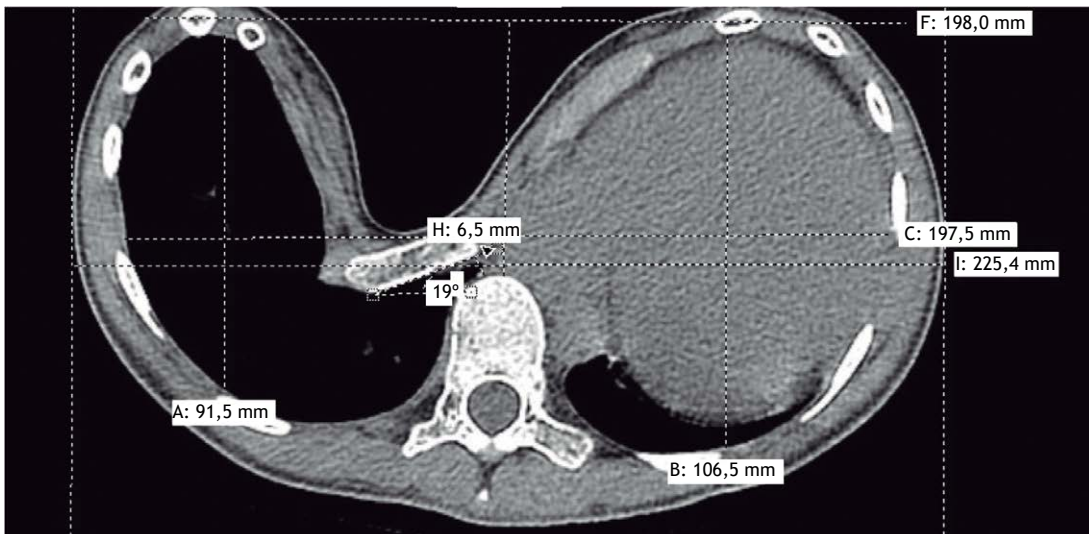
Computed tomography scan of patient 4 (Haller index of 30.3).
